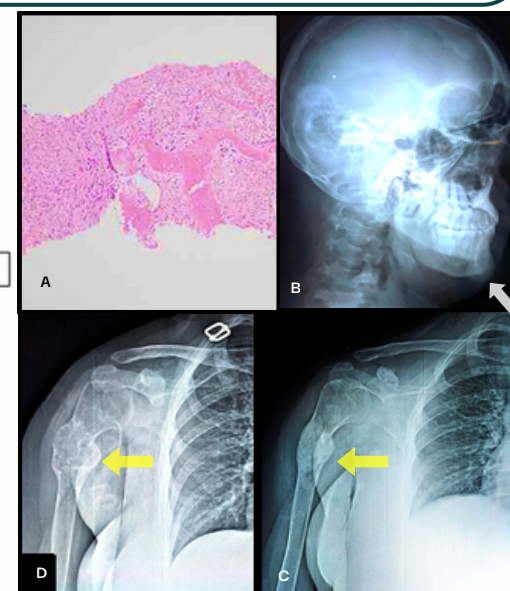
Pre-op radiograph and MRI of Rt shoulder and skull
